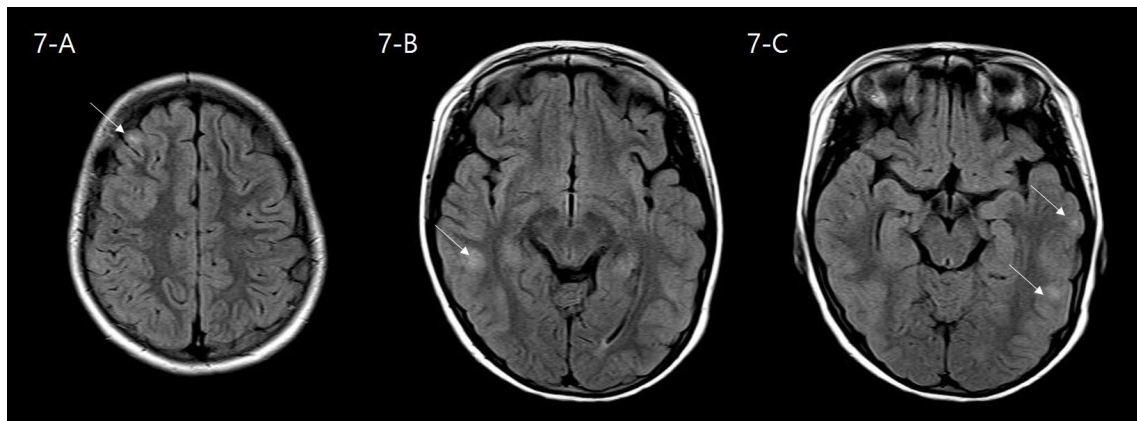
Brain MRI of patient 47 diagnosed with NMOSD (MOG antibodies positive) Multiple juxtacortical or subcortical lesions are shown on T2 FLAIR (A,B,C).MRI, magnetic resonance imaging; MOG, myelin oligodendrocyte glycoprotein; FLAIR, fluid-attenuated inversion recovery
